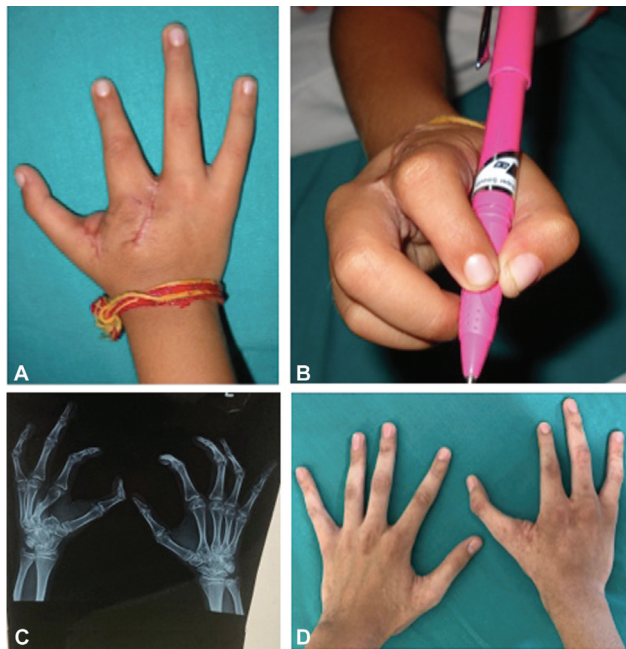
(A and B) Postoperative photographs at 6 months for cases 1. (C) Postoperative radiograph at 2 years. (D) Postoperative result at 2 years with no widening of web space at previous cleft site.
